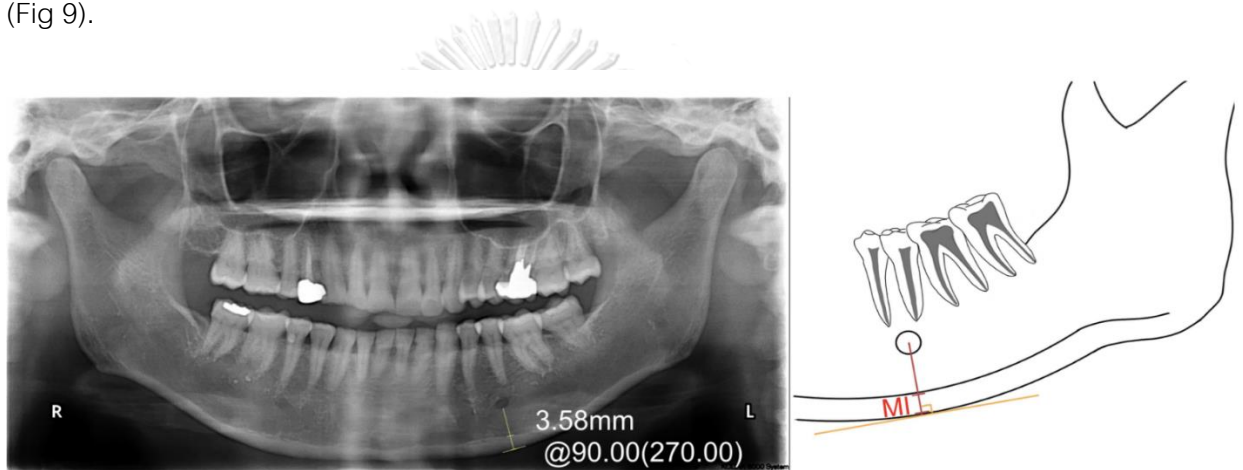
A panoramic radiograph showing MCI measurement. A line parallel to the long axis of the mandible and tangential to the inferior border of the mandible was drawn. A line perpendicular to this tangent intersecting the inferior border of the mental foramen was constructed, along which mandibular cortical width was measured.
